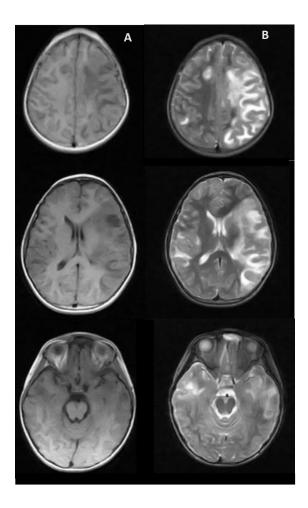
Cranial MRI showing T1 hypointensity (A) and T2 hyperintensity (B) over the left frontal, parietal, temporal, thalamocapsular region and right temporal
